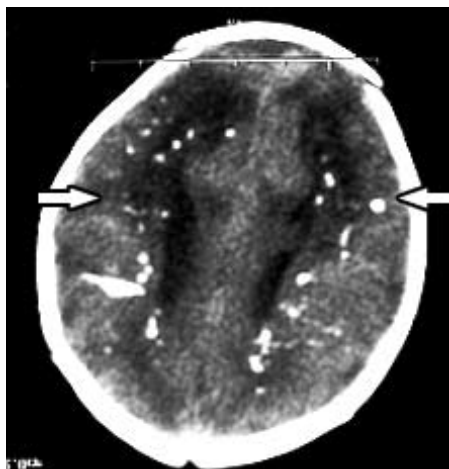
Brain CT scan of family I, patient 2, showing extensive periventricular calcification.
